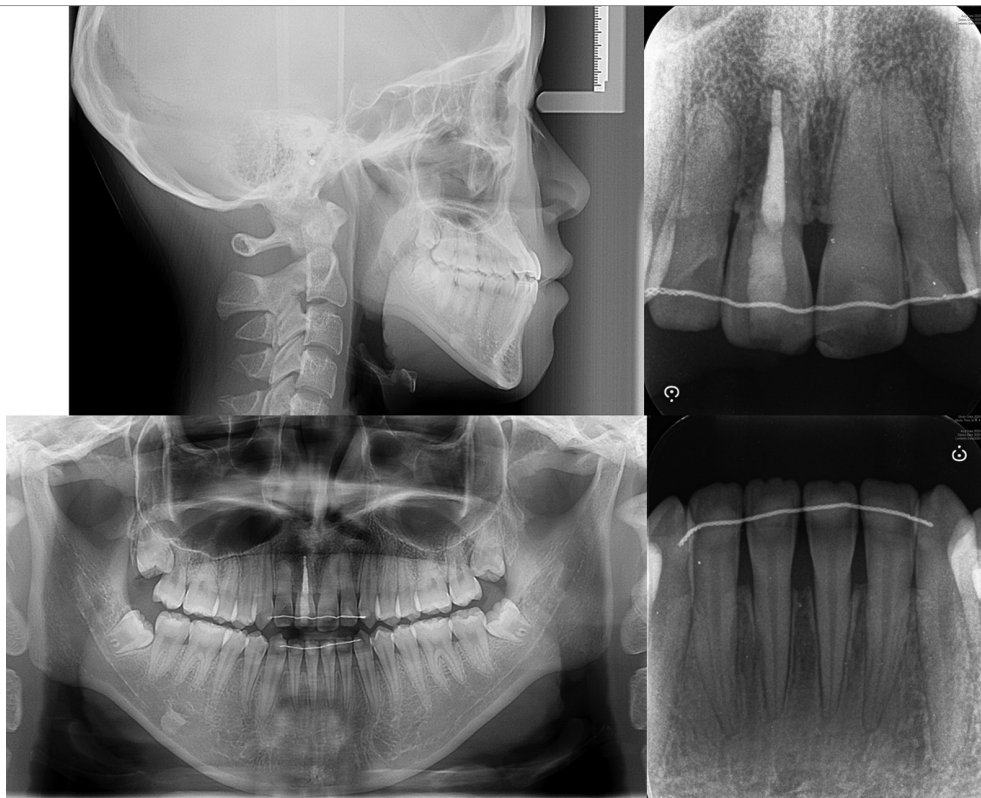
Radiographs 3 years after the completion of postoperative orthodontics
